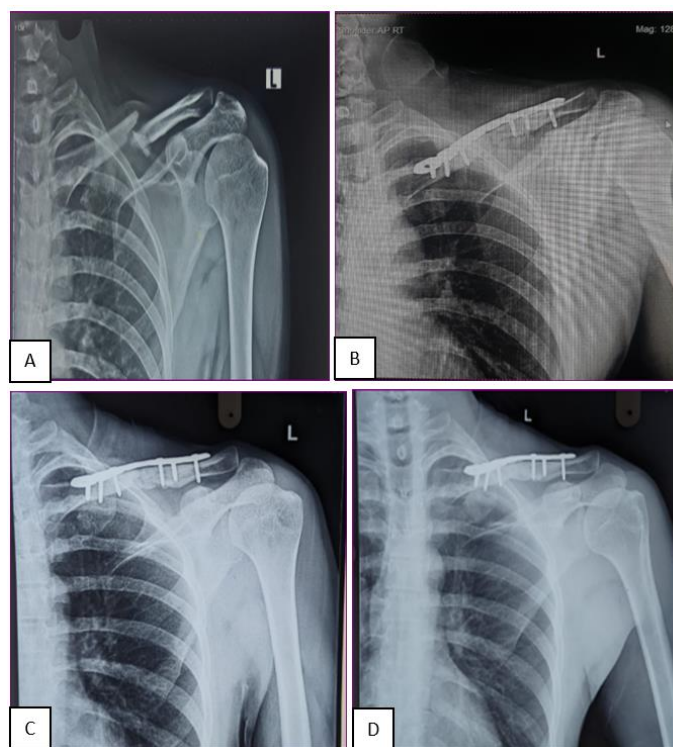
A): Pre-op x-ray of operated patient; B): Immediate post op x-ray; C): 3 month postop x-ray; D): 6 month post op x-ray
